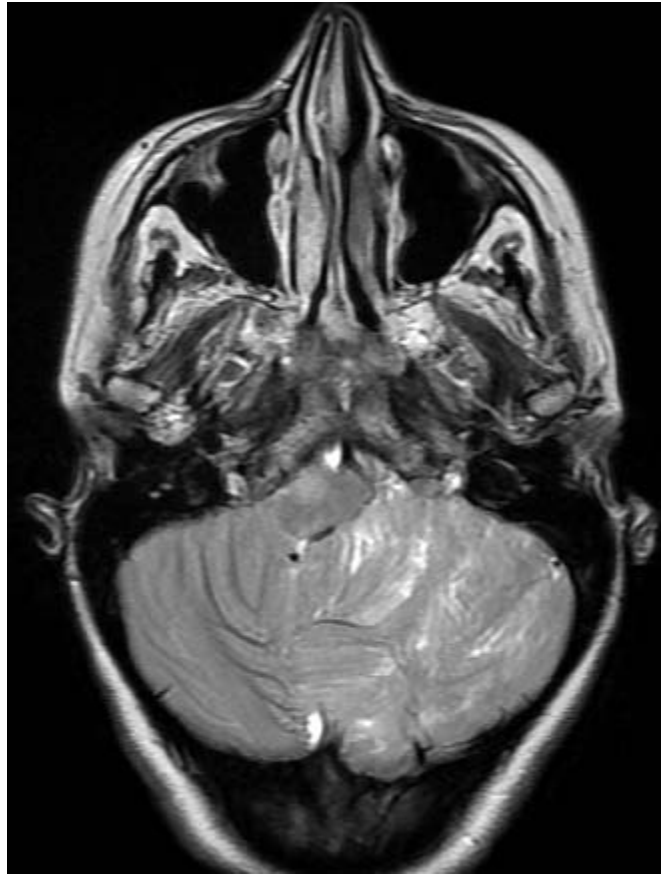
Axial T2-weighted magnetic resonance imaging of the brain showing the left cerebellar mass with widened cerebellar folia, a striated pattern, and preserved cortex. Note the retroclivaldural-based isointense mass on the right side representing retroclival meningioma.
